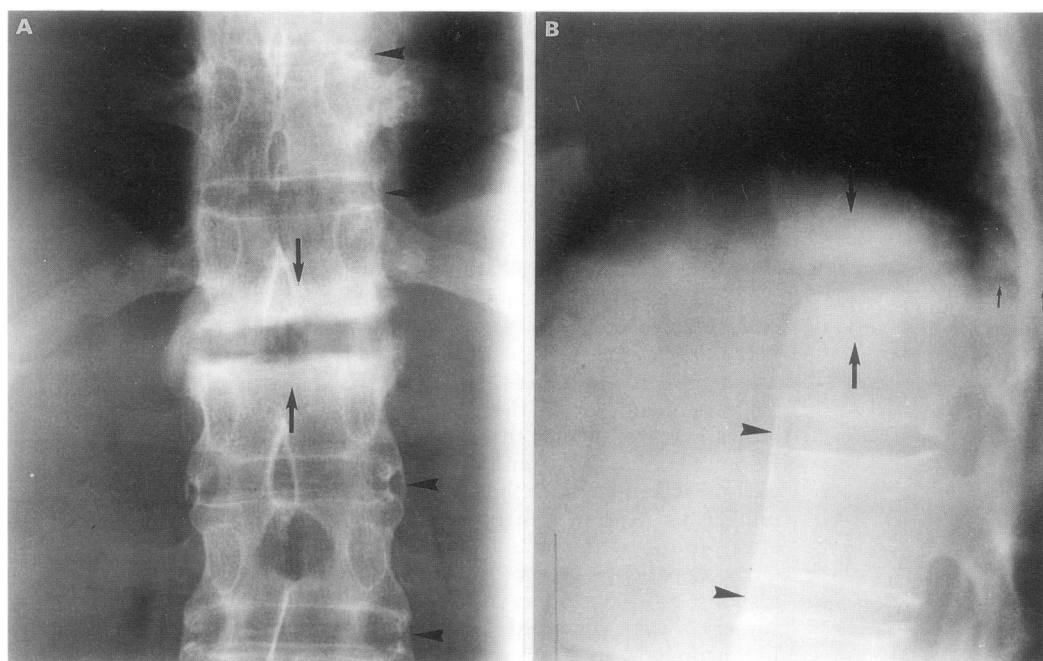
(A) AP and (B) lateral radiographs show T12/L1 pseudoarthrosis. There is destructive change at the intervertebral space with surrounding sclerosis (arrows). A transverse linear break continues through the fused posterior elements at the same level (small arrows). Syndesmophytes are present above and below this level (arrowheads).
